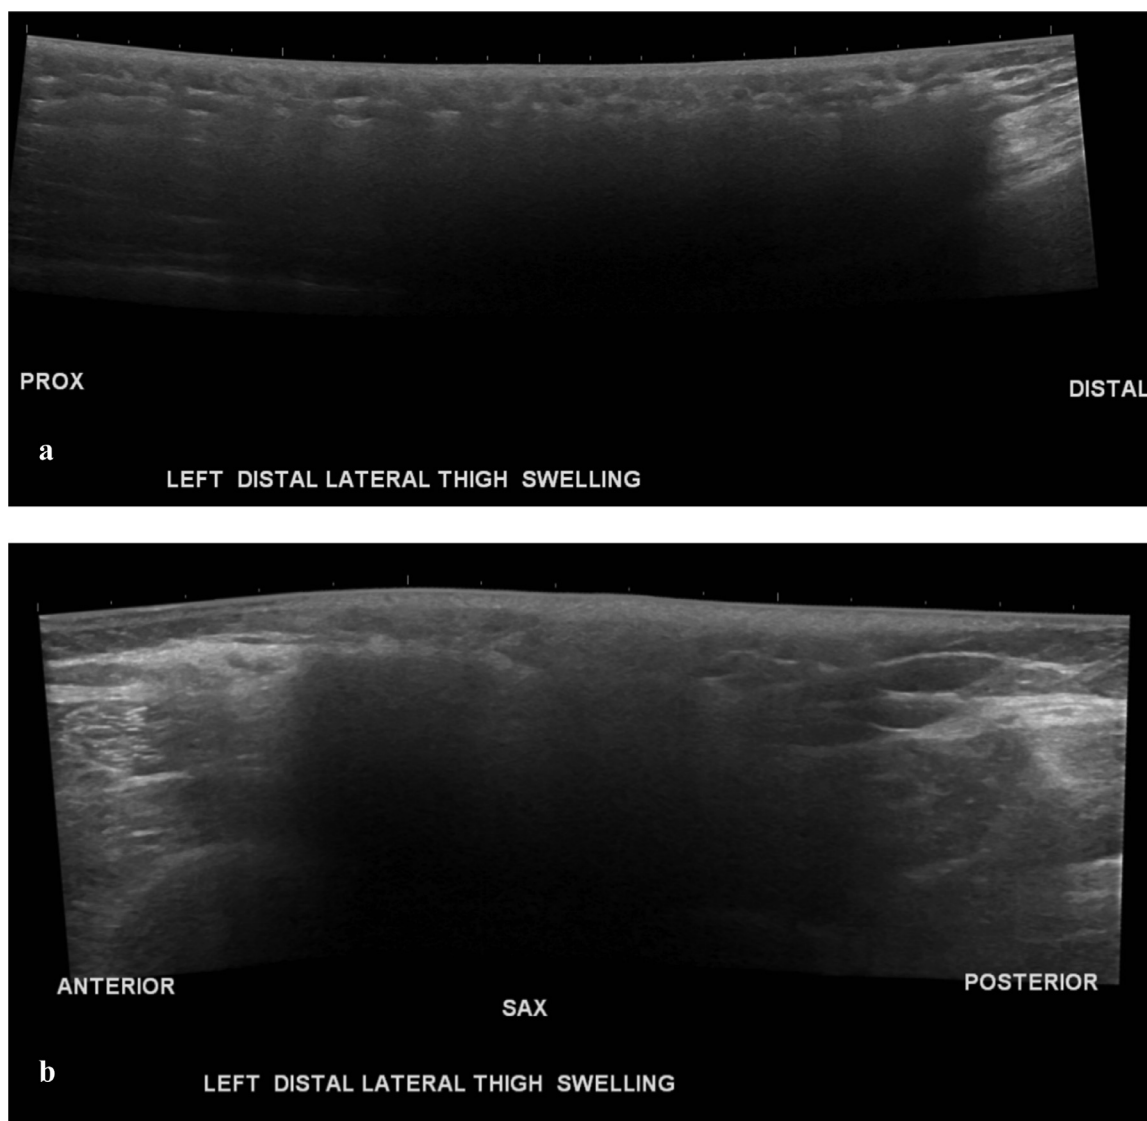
Ultrasound images of the area of concern at the distal lateral left thigh. (a) Long-axis and (b) short-axis (SAX) panoramic sonographic images demonstrating a “snowstorm” appearance with irregular hyperechoic shadowing, obscuring the underlying anatomy.
